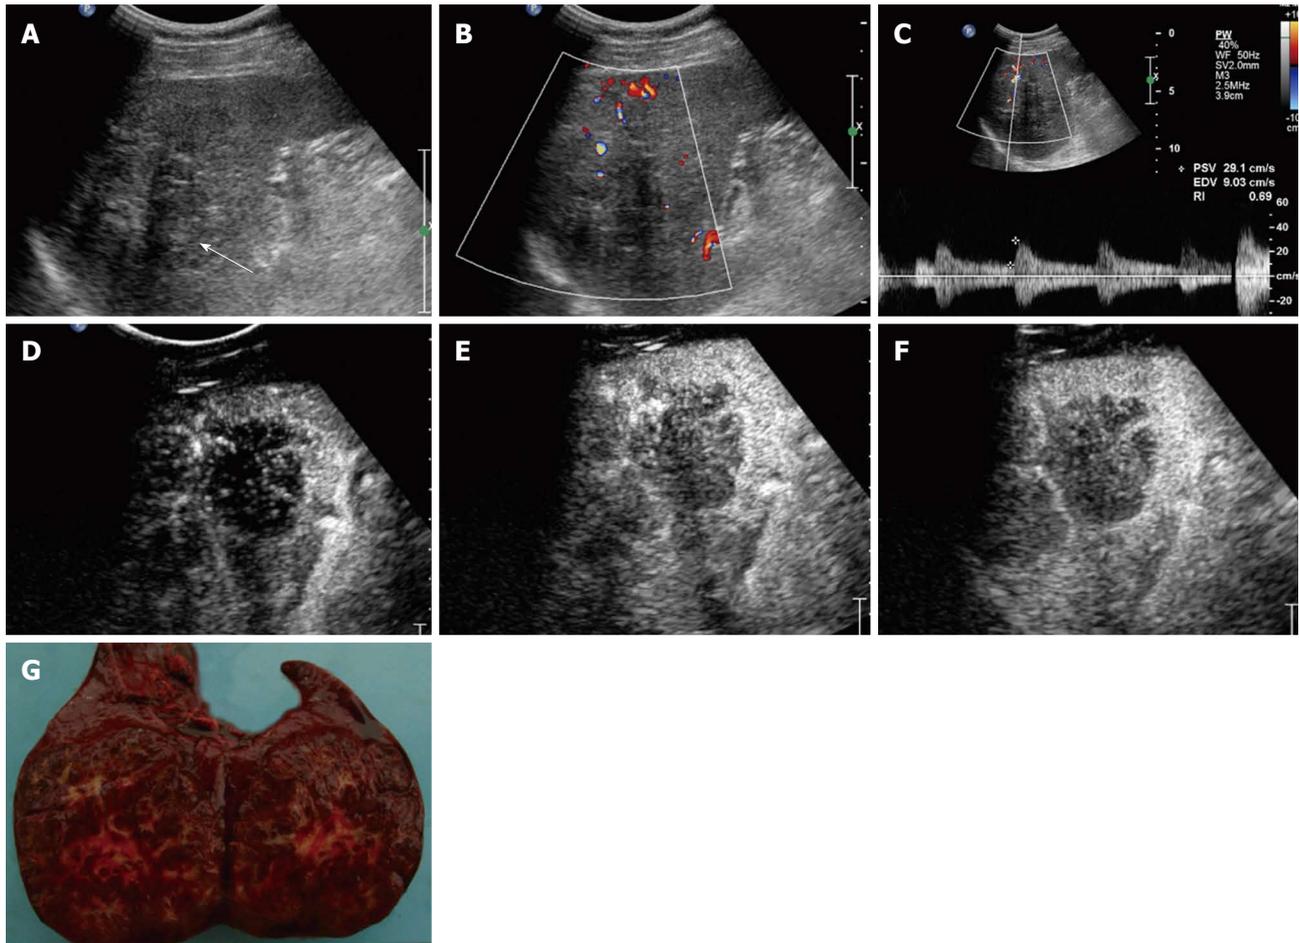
Conventional ultrasonography and contrast-enhanced ultrasonography findings of sclerosing angiomatoid nodular transformation in a 39-year-old man. A: A hypoechoic lesion (arrow) in the spleen; B and C: Color Doppler flow imaging shows branch-shaped and wire-like blood-flow signals inside and spot-shaped blood-flow signals in the periphery of the lesion; D: The lesion was enhanced in the branch-shaped diffuse pattern (15 s after injection); E: It presented heterogeneous lobular appearance when reaching its peak enhancement; F: Lots of septa inside the lesion; G: Surface of the lesion found during the operation.
